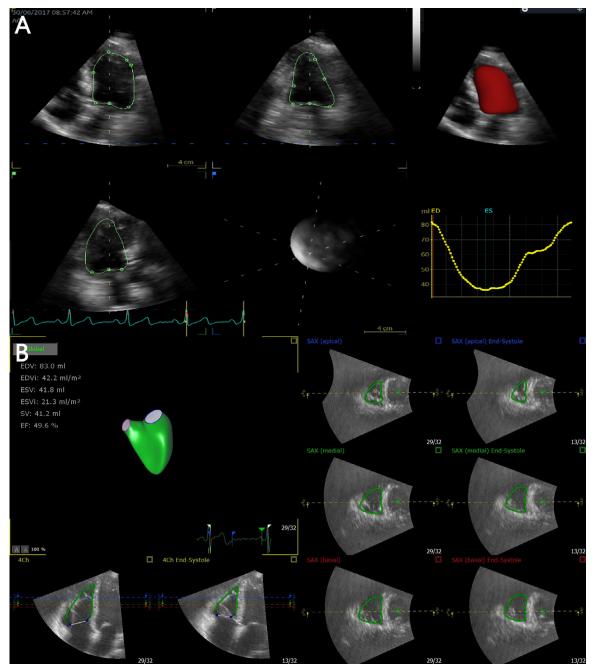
Three dimensional transthoracic echocardiograms with volumetric reconstruction of ventricular cavities (A) Left ventricular ejection fraction quantification using Echopac software (B) Right ventricular ejection fraction quantification using Tomtec software.
